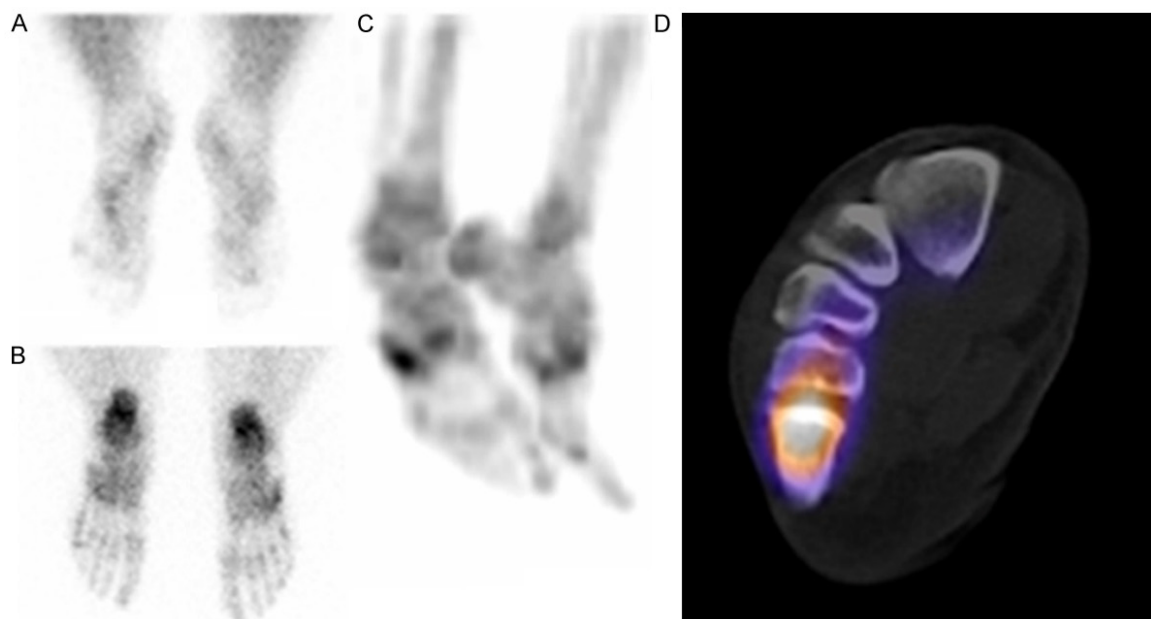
Plantar blood pool (A) images demonstrate relatively symmetrical activity in both feet. Delayed plantar bone images (B) show mildly increased uptake in the right 5th metatarsal and cuboid bone area. Maximal intensity projection (C) and axial (D) SPECT-CT images localize the uptake in the fifth proximal metatarsal, consistent with a stress fracture.
